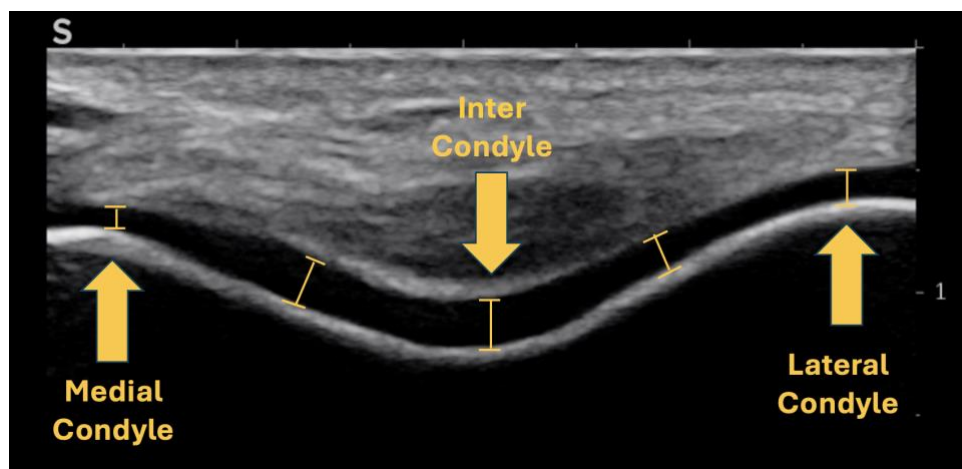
An ultrasound image of the knee showing the three condyles and where measurements will be taken.
